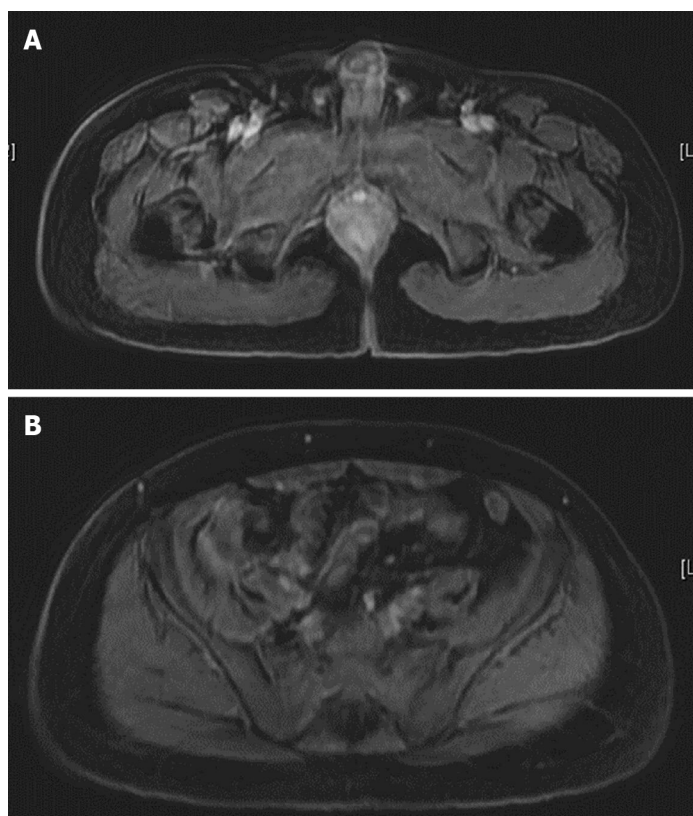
Magnetic resonance imaging seven months after diagnosis. A: No more rectal fistula tract; B: No more presacral abscess.
